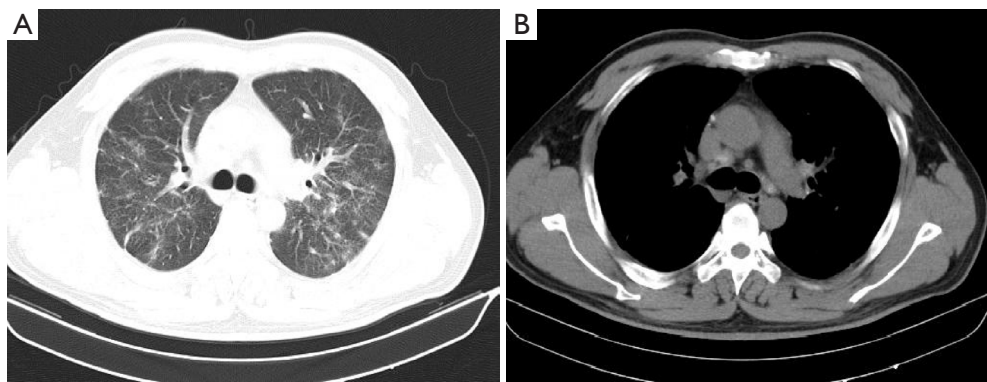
Chest computed tomography scan on April 15, 2021. (A) Cord-like high-density shadows in the upper sections of both lungs. (B) Pronounced mediastinal and hilar lymph node enlargement.
